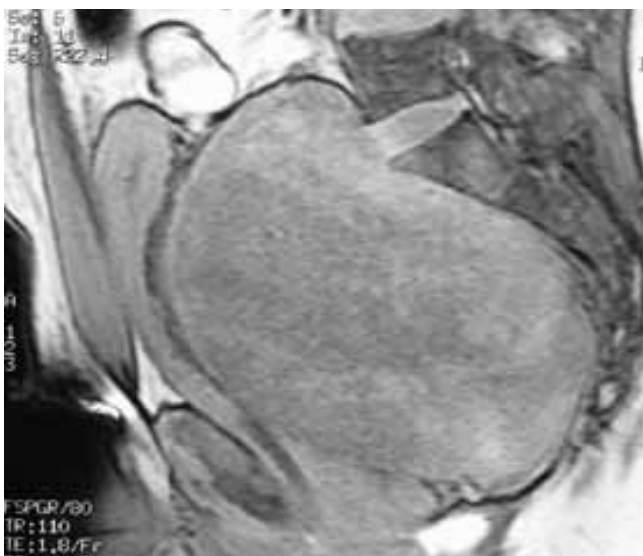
Abdominal T1-weighted MRI with gadolinium revealed large, presacral tumorous mass.
